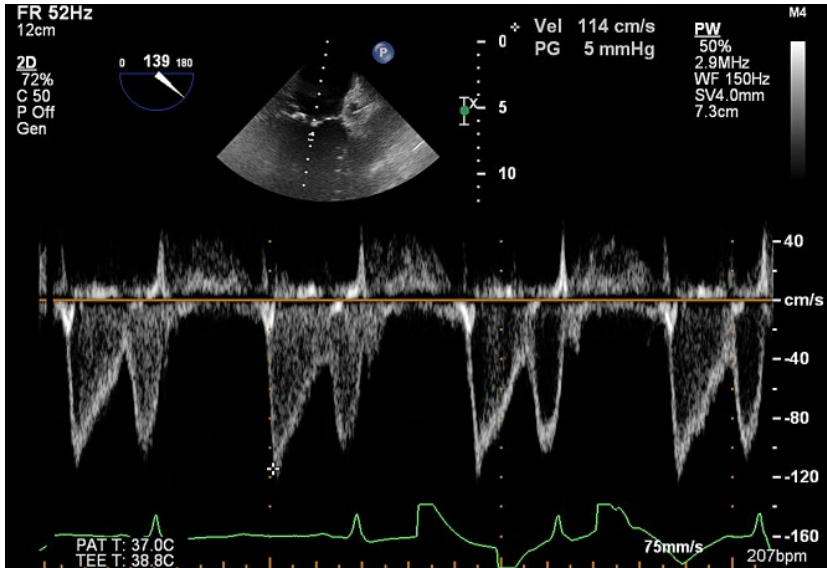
TOE Doppler tracing showing mitral inflow E and A waves.
